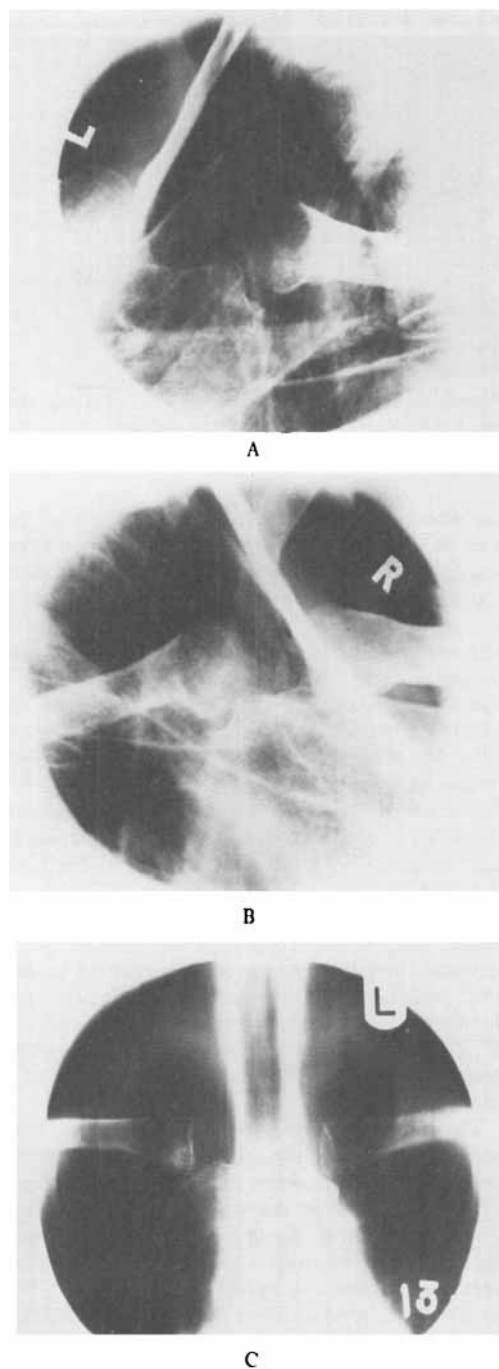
Radiographs of the same patient as Figure 1 with subluxation of the right sterno-clavicular joint. (a) Normal left joint. (b) Right joint, unremarkable appearance. (c) Tomogram of both joints. Cystic changes seen at the medial end of the clavicle on the affected side.
